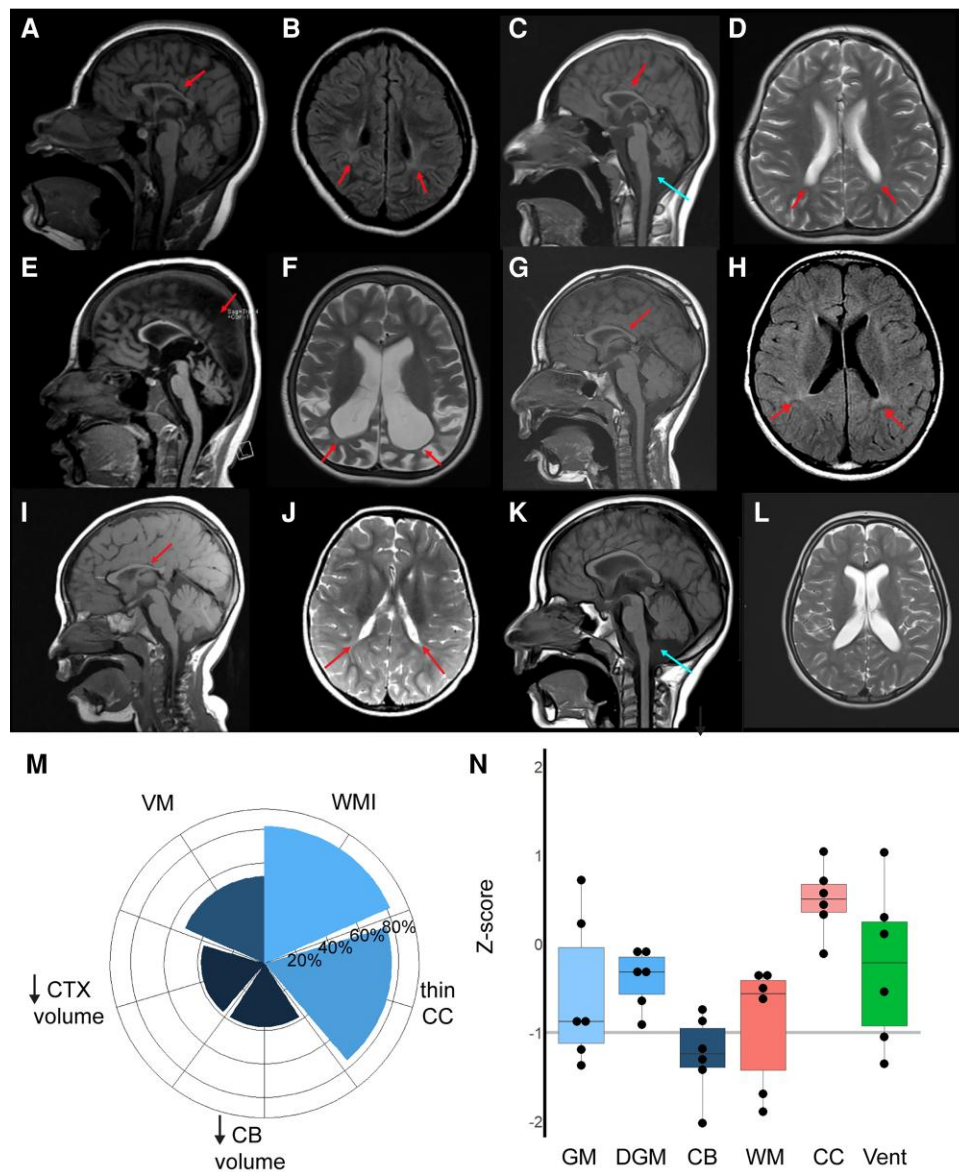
Qualitative and quantitative analysis of MRI images. (A, C, E, G, I and K) Sagittal MRI T1-weighted midline images. (B and H) Axial fluid attenuated inversion recovery (FLAIR) images. (D, F, J and L) Axial MRI T2-weighted images. (A and B) Patient 3, Family 2: 13-year-old female. (A) Small craniofacial ratio, thinning/foreshortening of the corpus callosum with greater involvement of the posterior fibres (red arrow). (B) Patchy FLAIR signal hyperintensity in the bilateral periventricular white matter (arrows) extending to the centrum semiovale, perirolandic and periatlial regions (not shown). (C and D) Patient 5, Family 4: 13-year-old female. (C) Small craniofacial ratio, diffuse thinning/foreshortening of the corpus callosum (red arrow) and brainstem and cerebellum volume loss (cyan arrow). (D) Abnormal angulation of the posterior margins of the ventricles (arrows). (E and F) Patient 6, Family 4: 9-year-old female. (E) Small craniofacial ratio, thinning/foreshortening of the corpus callosum and posterior greater than anterior parenchymal loss (arrow). (F) Diffuse parenchymal loss with preferential involvement of the posterior lobes, ex-vacuo dilatation and angulation of the ventricles (arrows). (G and H) Patient 13, Family 10: 6-year-old male. (G) Reduced frontal occipital diameter (FOD) and diffuse thinning and foreshortening of the corpus callosum (arrow). (H) Patchy FLAIR signal hyperintensity in periatlial white matter associated with abnormal square shape of the posterior margins of the lateral ventricles (arrows). (I and J) Patient 14, Family 10: 2-year-old female. (I) Reduced FOD, diffuse thinning and foreshortening of the corpus callosum (arrow). (J) Increased T2 signal in periatlial white matter associated with abnormal angulation of the posterior margins of the lateral ventricles (arrows). (K and L) Patient 16, Family 10: 5-year-old female. (K) Marginal FOD (red arrow) and inferior vermis hypoplasia (cyan arrow). (L) No signal abnormalities present. (M) Phenogram of MRI features for 16 new patients and 7 previously reported patients with MRI interpretation. Patient-specific details are provided in [Supplementary Table 1](#). (N) Box and whisker plot of six structural measures quantified from brain MRI volumes of six patients, represented as z-scores in comparison to an age-matched control cohort of typically developing children. The threshold for significance of -1 SD indicates reduced volume compared to the general population. Volume loss was identified in the cerebellum, but there was no consistent reduction in other measurements. Ventricle asymmetry measures laterality of ventricle expansion; no asymmetry was detected. Boxes represent 25th and 75th percentiles with median line; whiskers represent data range. CB = cerebellum; CC = corpus callosum; CTX = cortex; DGM = deep grey matter; GM = grey matter; Vent = ventricle asymmetry; VM = ventriculomegaly; WM = white matter; WMI = white matter hyperintensity or abnormalities.
